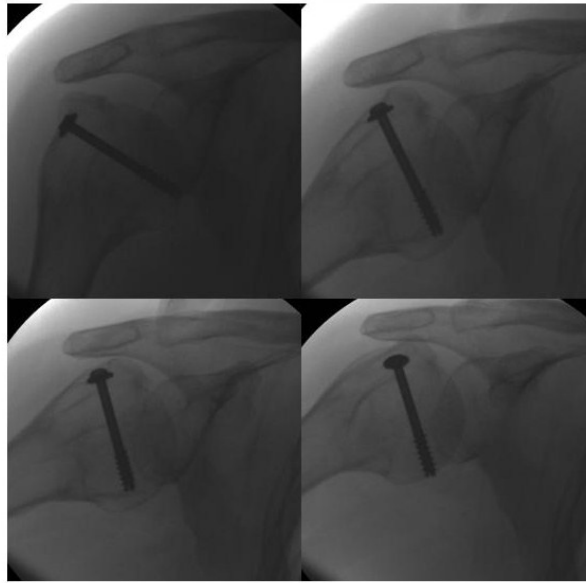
Intra-operative screening radiographs demonstrating a mechanical block to abduction due to the greater tuberosity
